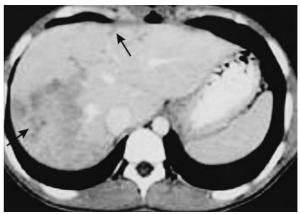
CT showed low-density masses with hazy margins located in the center and right lobe of the liver (arrow) and multiple tubular low-attenuated lesions extending to the subcapsular region at the periphery of left hepatic lobe (arrow)
